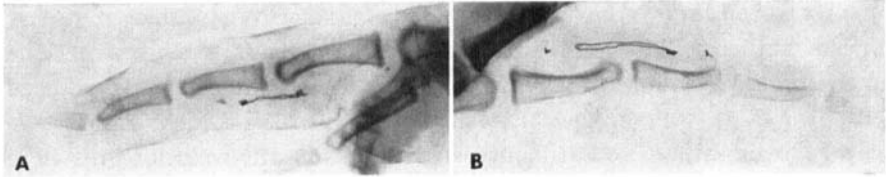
Roentgenographic appearance of the regular Bunnell's figure-eight suture (A). When not immobilized, this suture allows longitudinal separation of the proximal fragment and its retraction into the palm (B).
